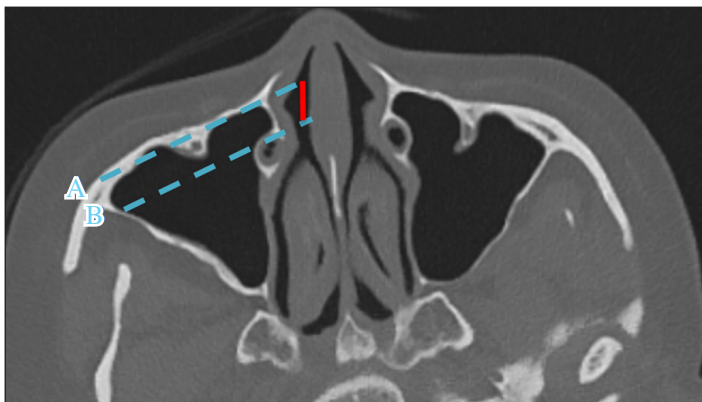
Paranasal Sinus CT scan, axial view. Line A corresponds to the anterior maxillary wall and Line B corresponds to the anterior border of the lacrimal duct. The solid vertical line corresponds to the prelacrima window.
